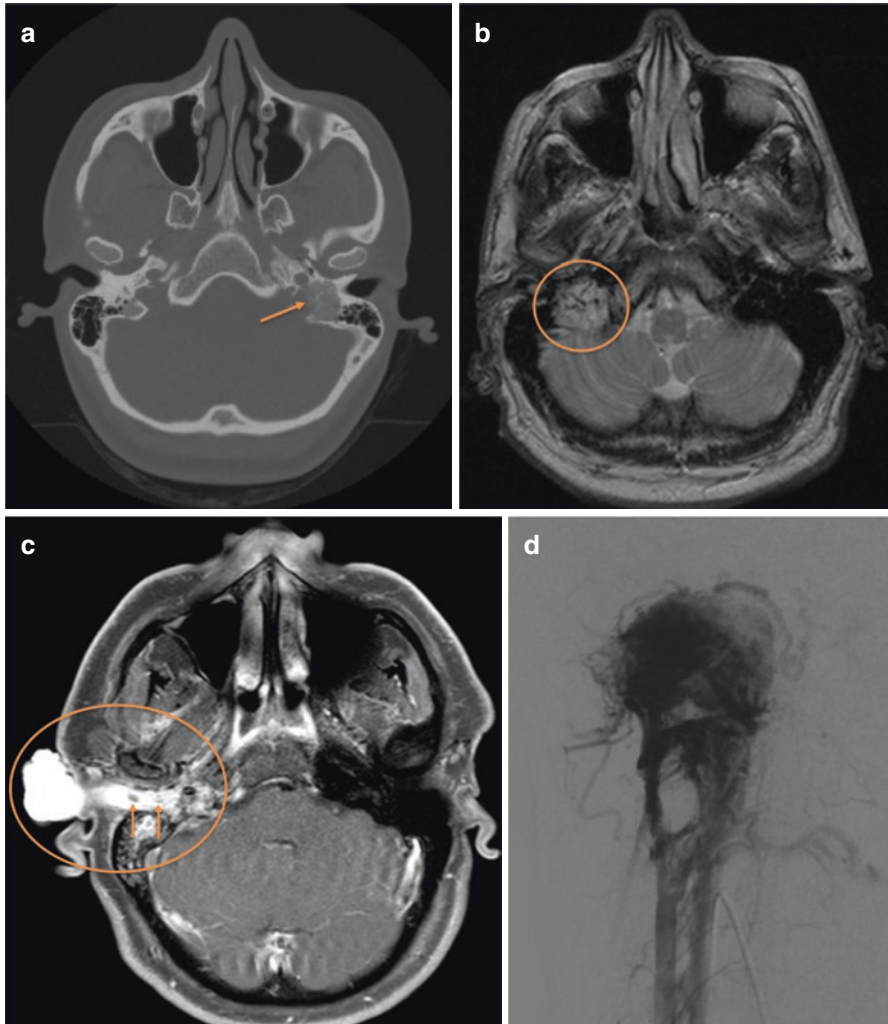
(a) Tomography with erosion of the jugular spine and presence of bone permeation in the left jugular foramen. (b) T2 resonance with hyperintense lesion and salt and pepper appearance. (c) T1-weighted contrast resonance showing a lesion in the jugular foramen that extends to the external auditory canal and presents sign flow-void areas. (d) Digital angiography of the paraganglioma vascularization
